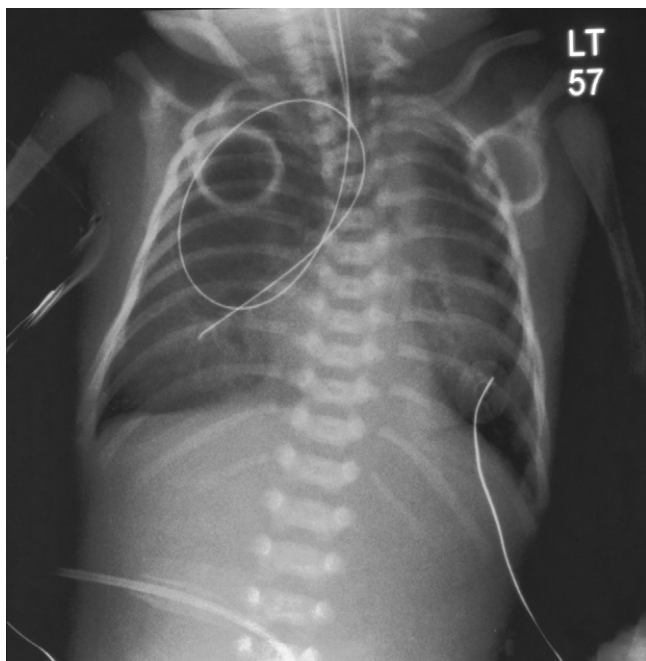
Chest radiograph with feeding tube curled up in right hemithorax. Cervical vertebral body ossification centres are absent.
